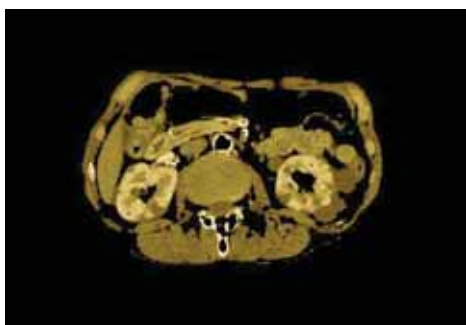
Cluster 1 of CT image with kidney cysts
